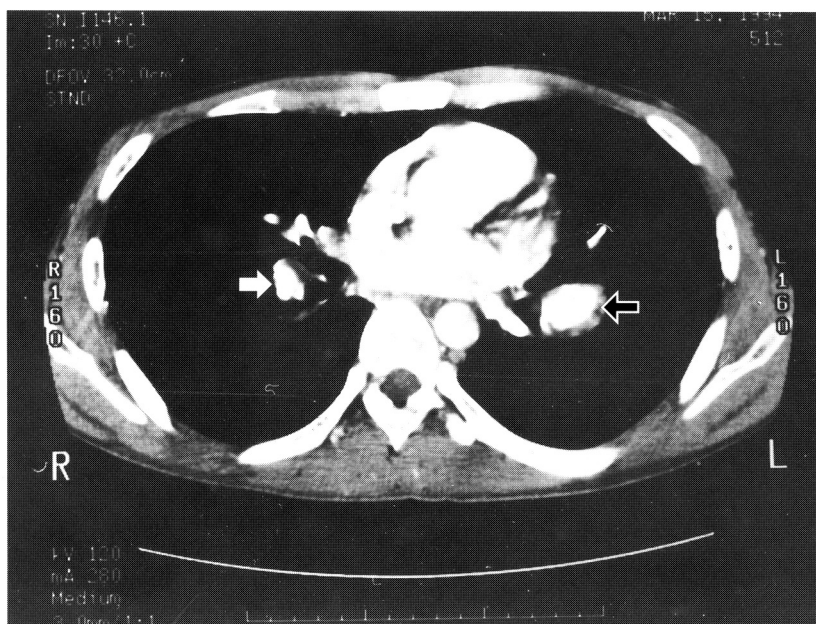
CT scan of the chest with contrast showing partially thrombosed aneurysm of the left lower lobe artery with a diameter of 2.5cm(open arrow) and small aneurysm of the right lower lobe artery(white arrow).
